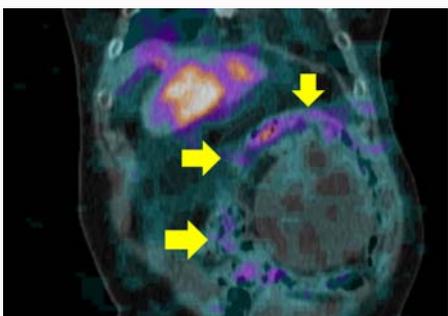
I-123 MIBG SPECT showed huge mass with mild peripheral uptake of left adrenal gland.
